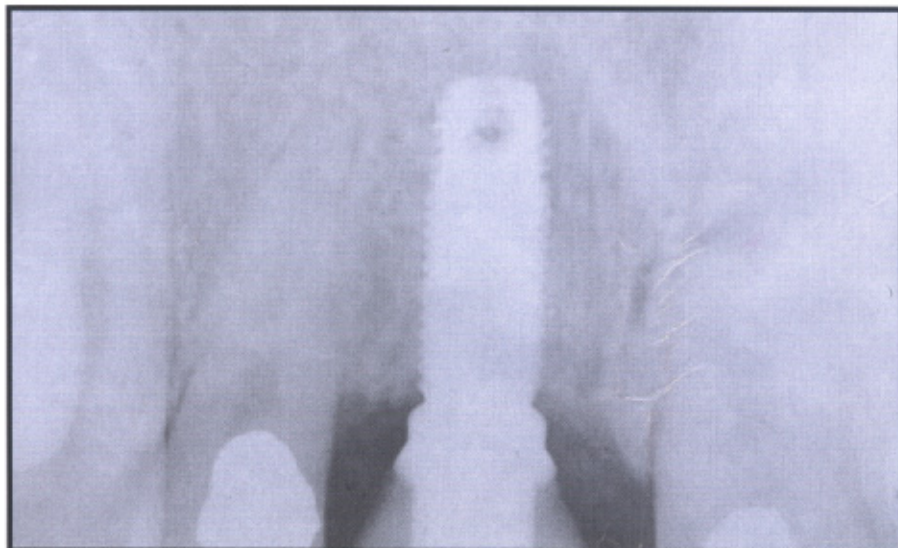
Radiograph of the implant/abutment/crown system exhibits the precise fit of all elements.
